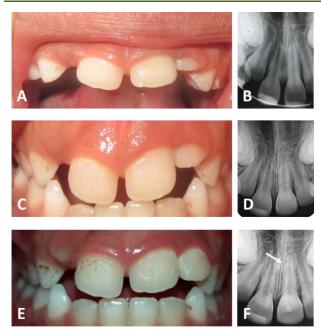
Clinical and radiographic examination: up to six months after replantation; A) Clinical examination: 15 days post-replantation, after removing the splint. B) Radiographic examination: 15 days post-replantation, just before removing the splint. C) Clinical examination: 2 months post-replantation. D) Radiographic examination: 2 months post-replantation. E) Clinical examination: 6 months post-replantation. F) Radiographic examination: 6 months post-replantation
